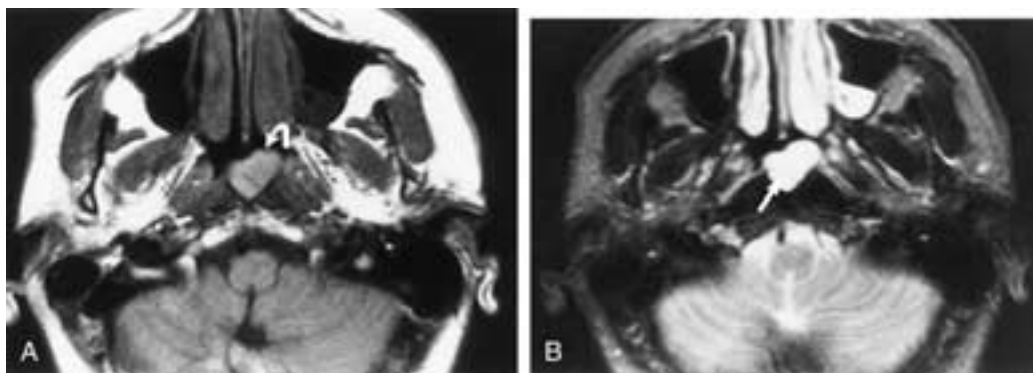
A, Axial T1-weighted noncontrast MR image shows a well-delineated lesion (*arrow*) with increased signal intensity located within the nasopharynx. This was a Tornwaldt's cyst. B, There is increased signal within the lesion on the T2-weighted sequence, which is consistent with the cystic nature of the mass. Note the internal septation present within the lesion (*arrow*).
